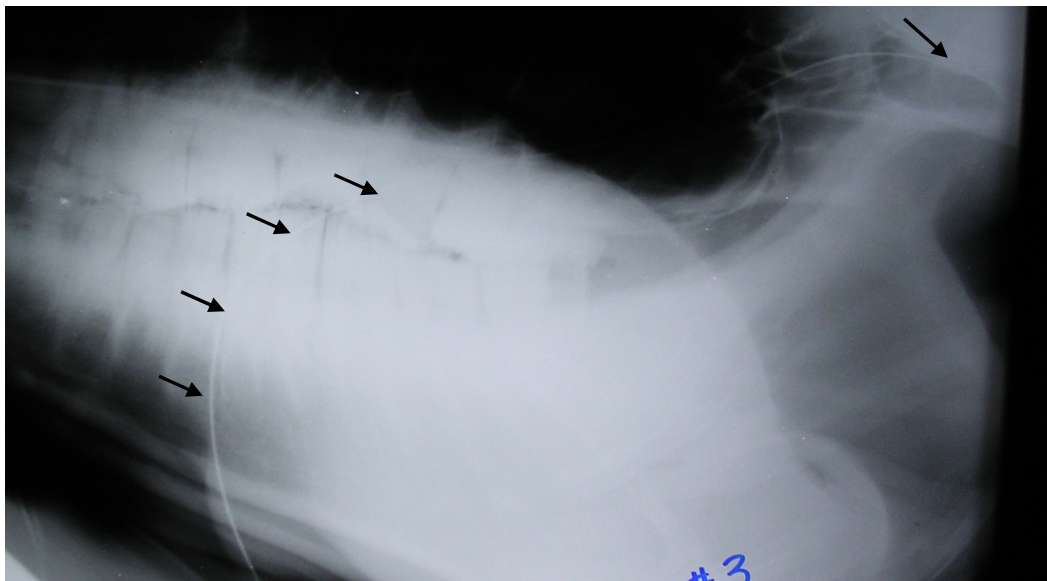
Lateral radiograph post-catheterization. Arrows help identify the catheter with the guide wire still in place as it travels toward the cranium into the ICS and the tip resting just below the orbit of the eye.
